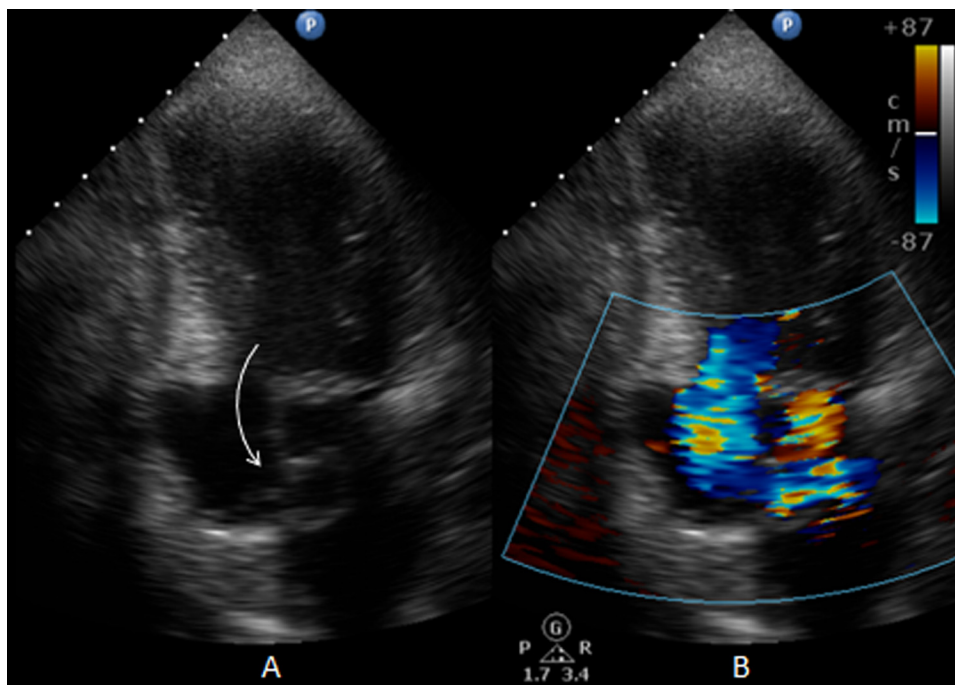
Transthoracic apical 2 chamber, 2D-Echo (A) and color image (B) showing the aneurysm tunneling through the submitral space into left atrium (curved arrow) with systolic regurgitation jet from left ventricle to left atrium via the aneurysm.
